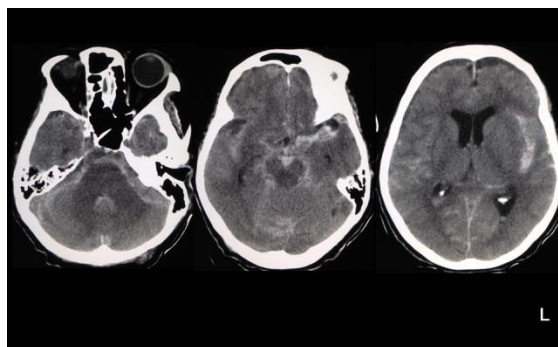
Head CT on arrival
